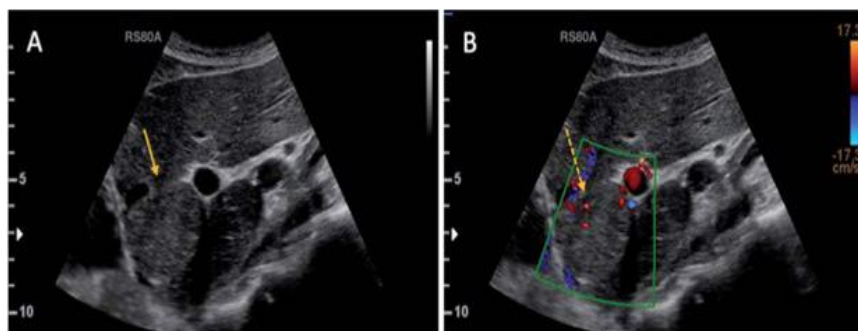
49-year-old male with no relevant medical history. A: 3,5cm isoechoic lesion in segment 4 found in B-Mode sonography. B: Color Doppler image demonstrates vasculature in the periphery.
